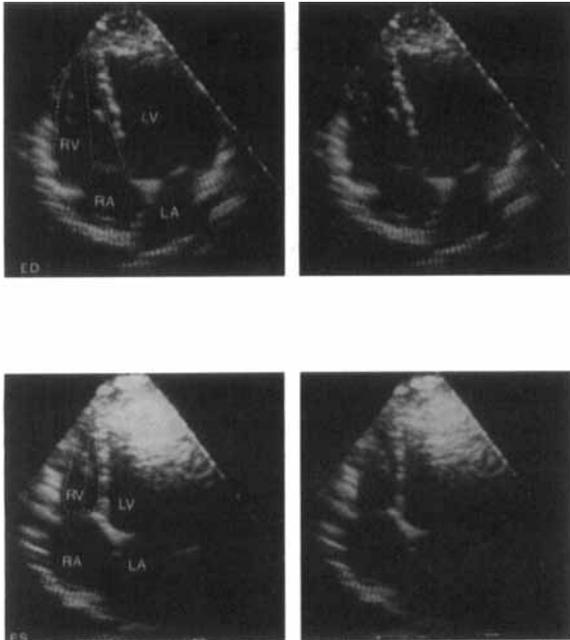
Apical four-chamber view with end-systolic (ES) and end-diastolic (ED) frames outlined demonstrating the method of planimetry used for calculation of right ventricular (RV) volumes and ejection fraction. LA = left atrium; LV = left ventricle; RA = right atrium. Reprinted with permission from Hiraishi et al.⁴
